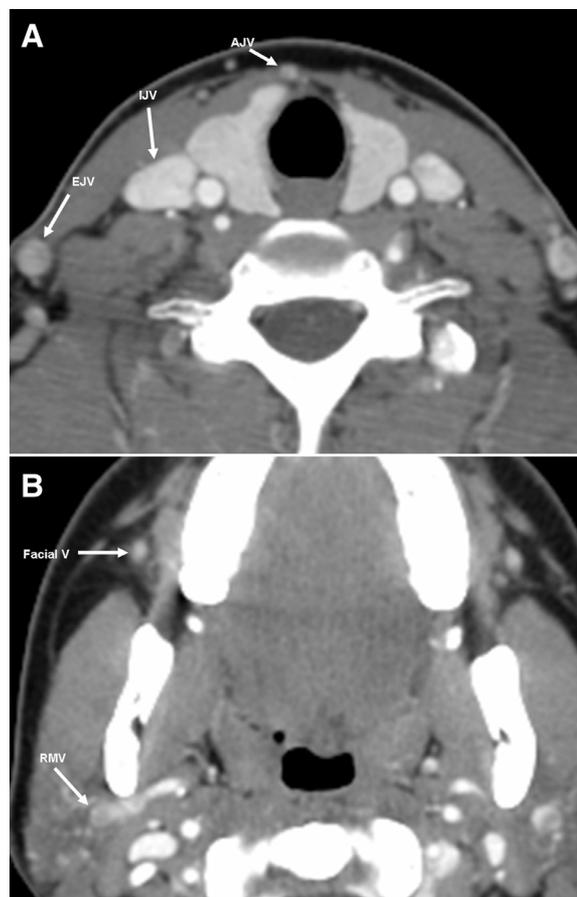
Axial images (A-B) from a contrast-enhanced CT through the neck and face. AJV, anterior jugular vein; EJV, external jugular vein; Facial V, facial vein; IJV, internal jugular vein; RMV, retromandibular vein.
